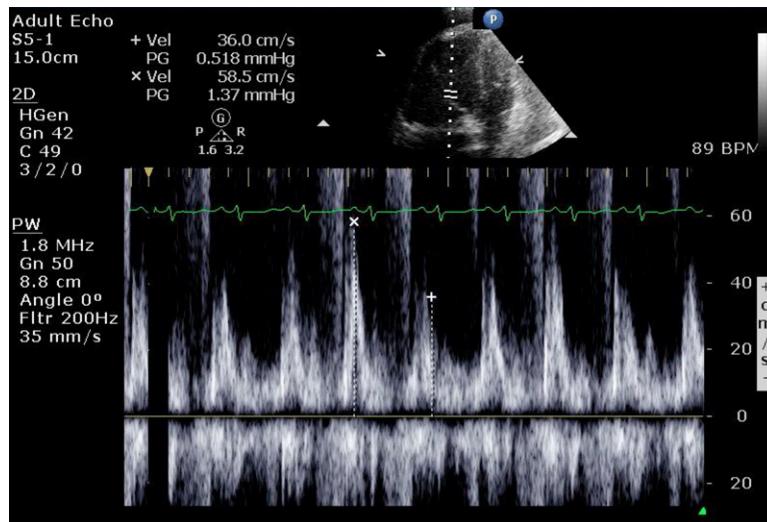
There is markedly exaggerated respiratory variation in transvalvular tricuspid inflow as assessed by pulsed wave Doppler. BPM = beats per minute; PW = pulsed wave.
